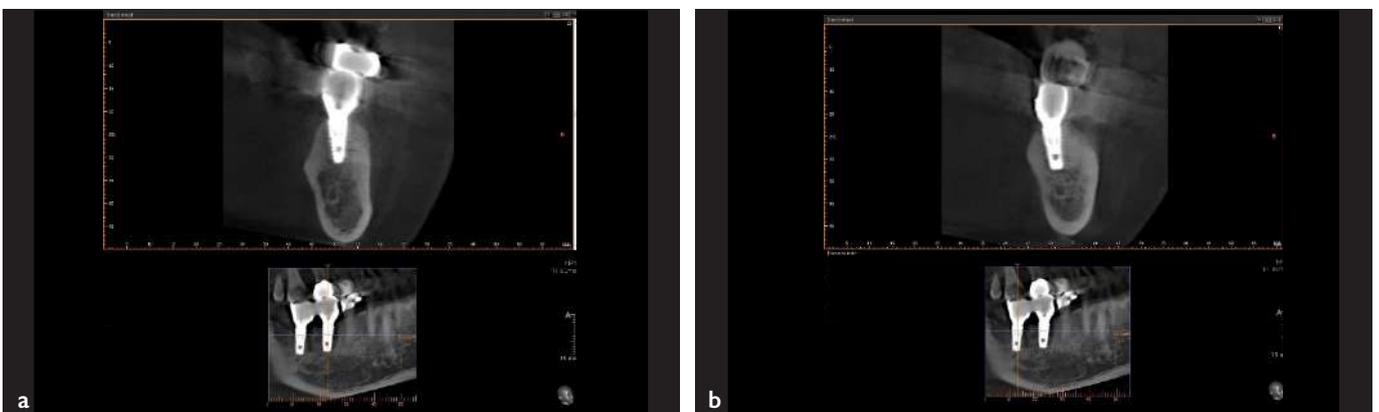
CBCT image of #46 and #47 site after bone augmentation(Note the successful buccal augmentation)
